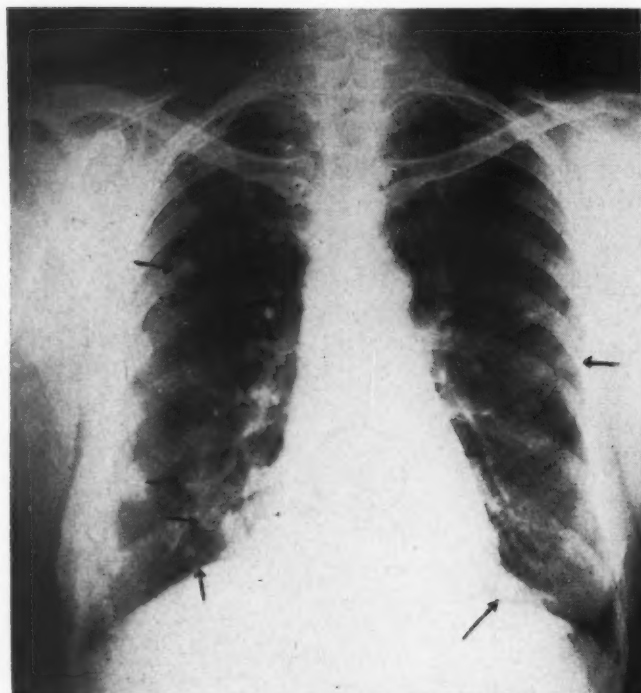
X-ray of patient showing cancer metastases in lung.
